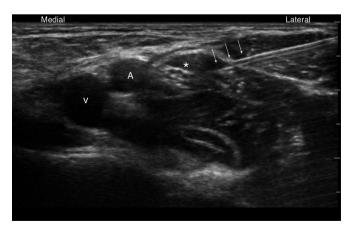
Ultrasound-guided femoral nerve block in a 3-year-old girl, demonstrating the anatomy (medial to lateral) vein, artery and nerve (\*) and the needle tip (arrows along shaft) with hydro-dissection of the fascial planes with local anaesthetic.
